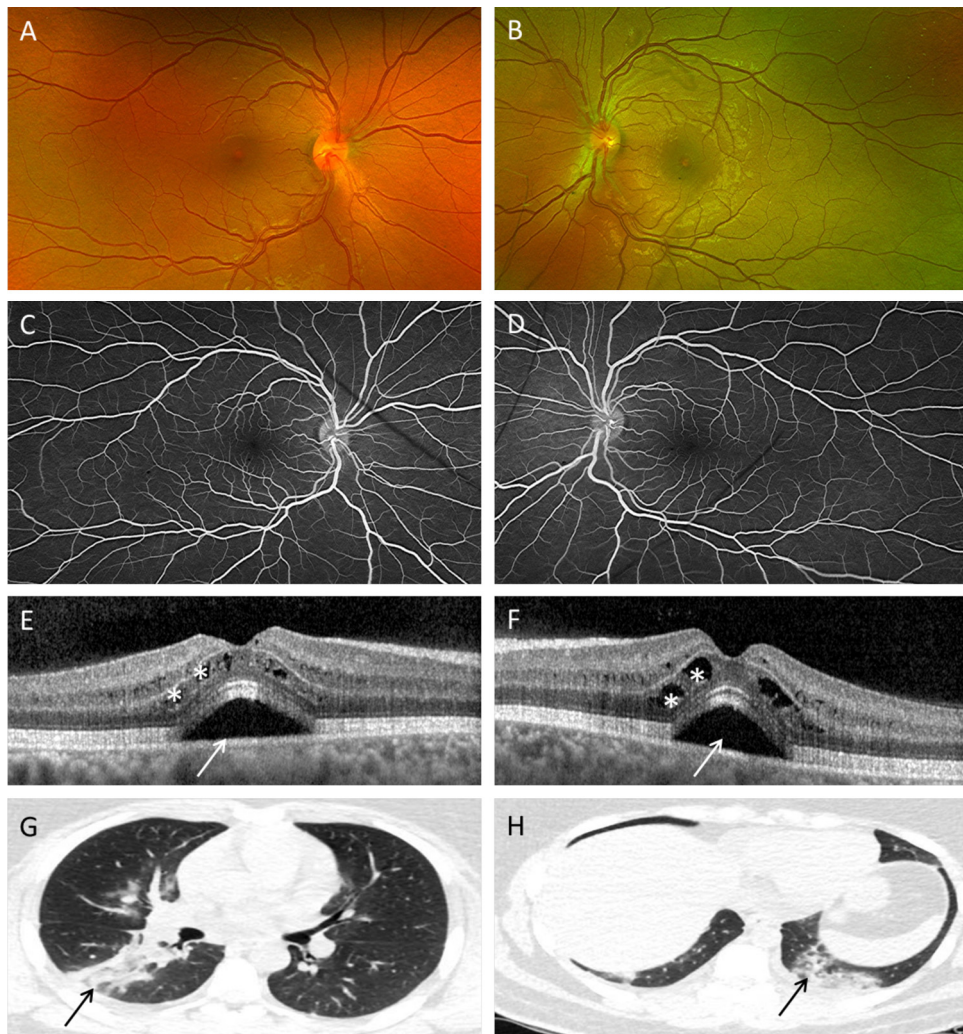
Bilateral SARS-CoV-2 cystoid maculopathy. A–B: Ultra wide-field color fundus photographs showing the absence of vitritis or papillitis and the presence of bilateral serous foveal detachments. C–D: Ultra wide-field fluorescein angiogram (late phase) showing absence of dye leakage at the level of the macula or optic nerve head. E–F: Optical coherence tomography showing a central foveal thickness (CFT) of 526 microns in the right eye (OD) (E) and 516 microns in the left eye (OS) (F). Bilateral serous detachment is present bilaterally (white arrows) and intraretinal cysts are observed in the inner nuclear layer, inner plexiform layer and outer nuclear layer (asterisks). G–H: Chest CT scans showing diffuse bilateral ground-glass opacities suggestive of SARS-CoV-2 infection (black arrows).
